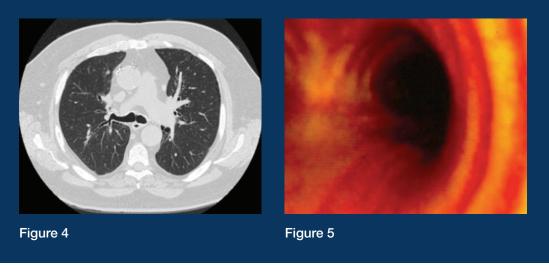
CT shows no evidence of recurrent disease at the right main bronchus, 1 year post-treatment.
